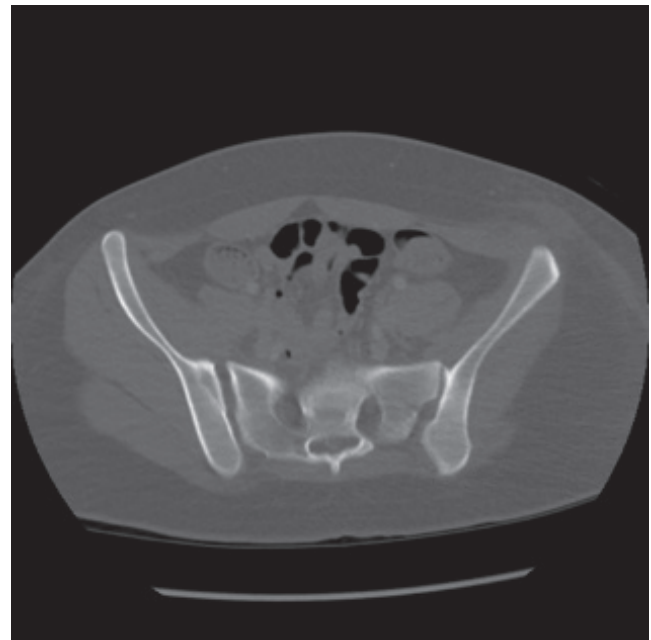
CT scan of a 15-year-old status post a motor vehicle collision with right sacroiliac joint widening. (a) axial image. (b) coronal image.
